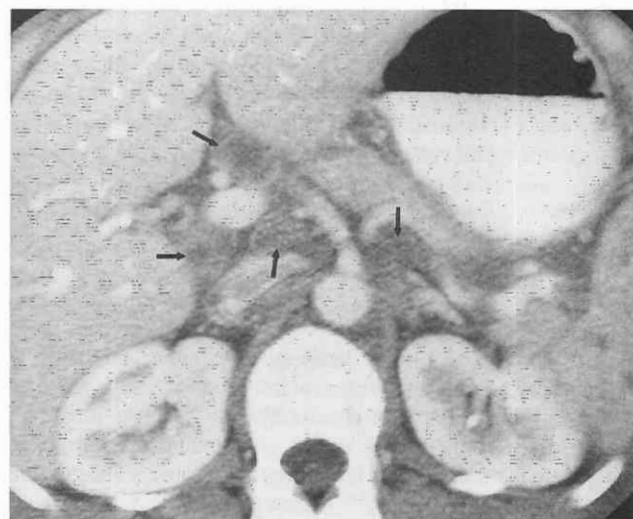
Mycobacterium tuberculosis* infection in a 50-year-old man with human immunodeficiency virus (HIV) infection. Enlarged, low-attenuation lymph nodes are identified on this contrast-enhanced CT image in the periportal, portocaval, and paraceliac regions (arrows).
